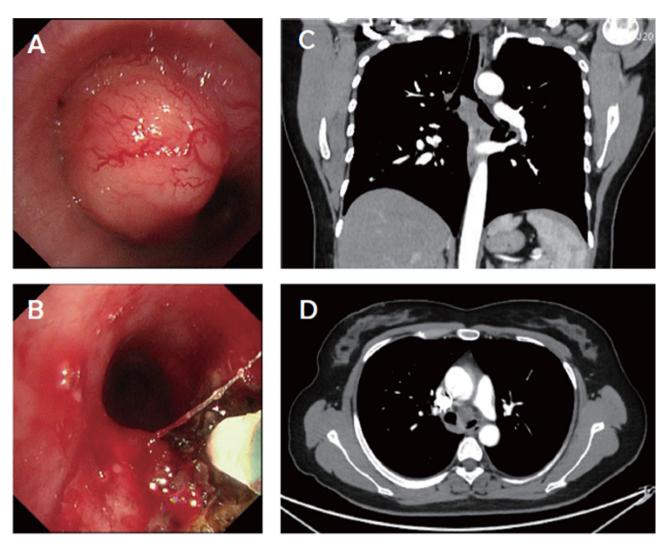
Preoperative examination. Bronchoscopy revealed a smooth neoplasm at the carina, which was subsequently treated with ablation therapy(A, B); Enhanced CT scan before surgery showed the tumor(C, D)
